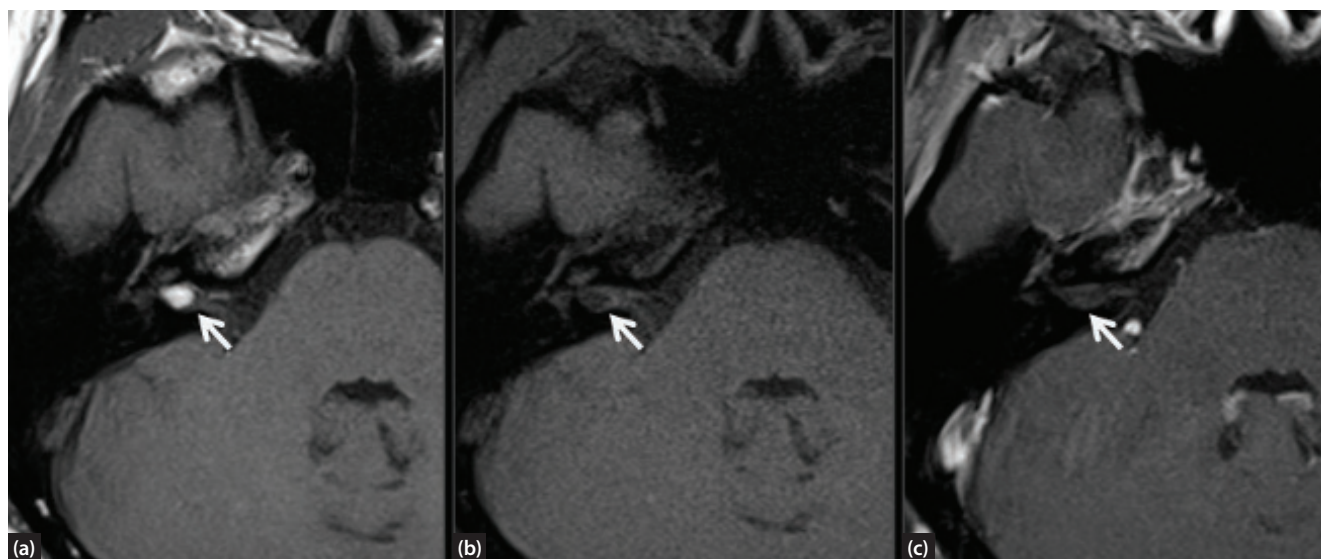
An intracanalicular right sided lipoma. (a) Very high signal intensity on axial non-contrast enhanced, T1-weighted imaging. (b) Hypointense on axial T1-weighted following fat suppression. (c) No enhancement following administration of gadolinium.
